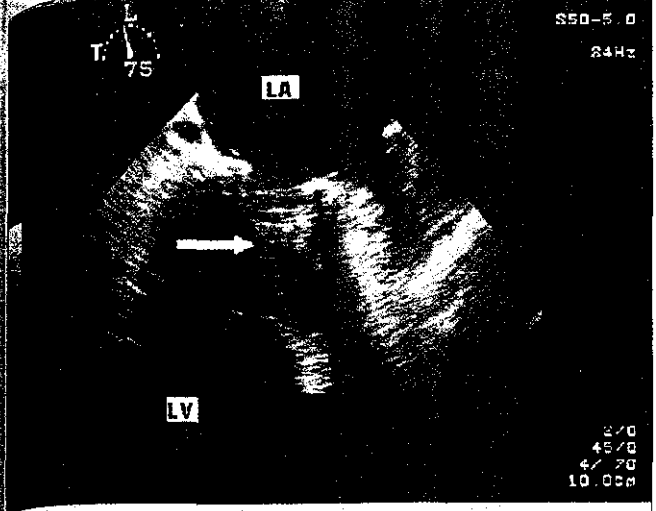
Transesophageal echocardiographic image of adequately functioning prosthetic valve.
